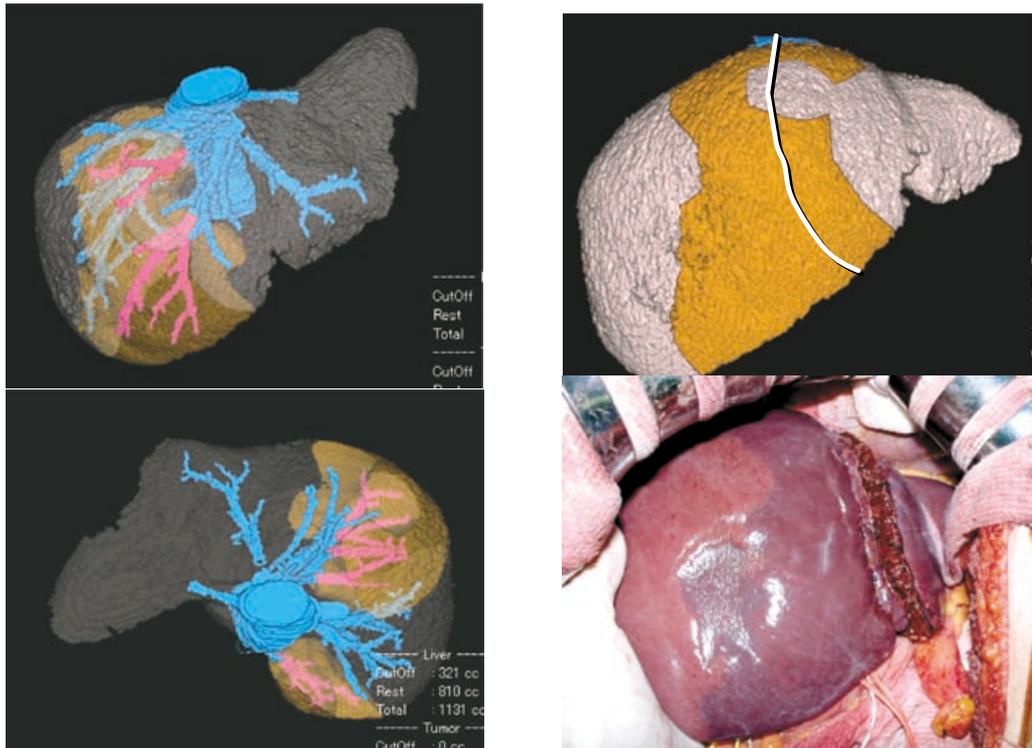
Three-dimensional computed-tomography (3D-CT) in the graft congestion. The 3D-CT expressed the congestive area in the liver when significant venous tributaries (V 5 and V 8) are transected. The actual photograph clearly demonstrated the congestive area coincident to the area in 3D-CT.
